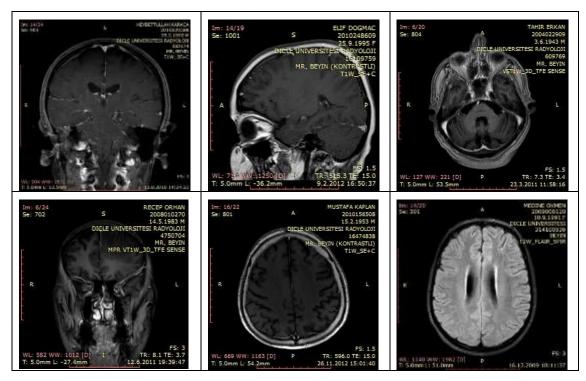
The samples of raw MRI images used in the study
